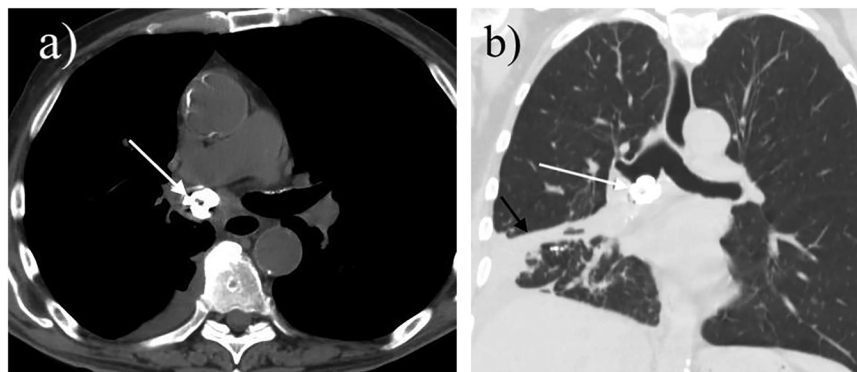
Non-contrast computed tomography examination of the chest in axial (a) and coronal planes (b). A broncholith is present within the right mainstem bronchus (white arrow). Note is made of post obstructive right lower lobe atelectasis (Fig. 1b; black arrow)
